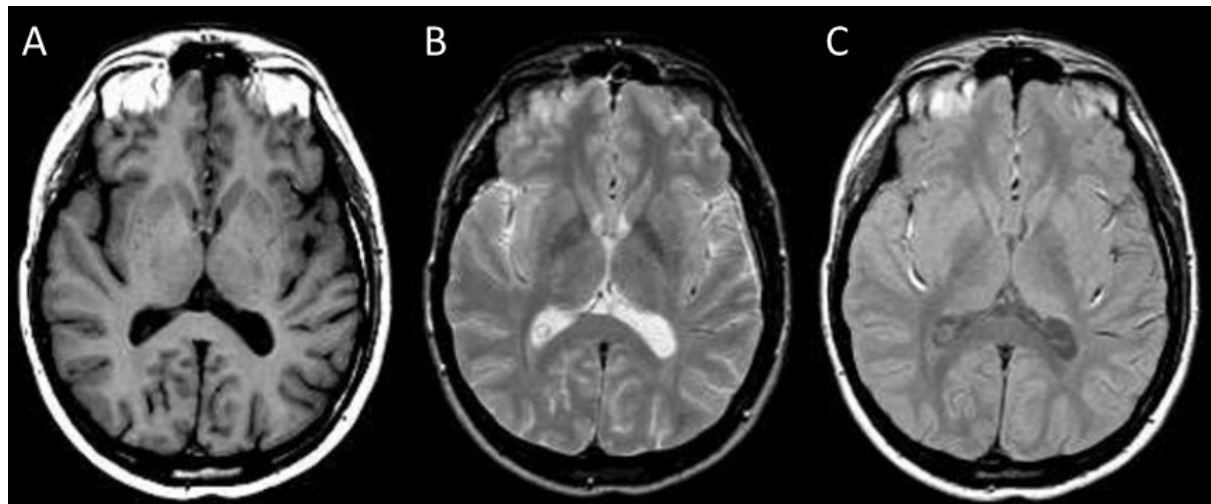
The same anatomy, imaged with a T1-weighted (A), a T2-weighted (B), and a proton density weighted (C) sequence. Reproduced from (34).
